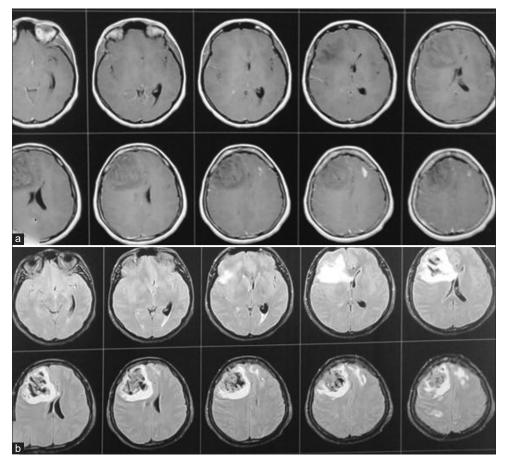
Case 1, (a) T1 WI with contrast showed right frontal intracerebral hemorrhage with surrounding edema, obliteration of ipsilateral frontal horn and displacement of contralateral horn with midline shift. (b) FLAIR image. The marked hypointensity of the ICH is most likely caused by the T2 shortening effects of intracellular methaemoglobin present abundantly in the clot at this stage.
